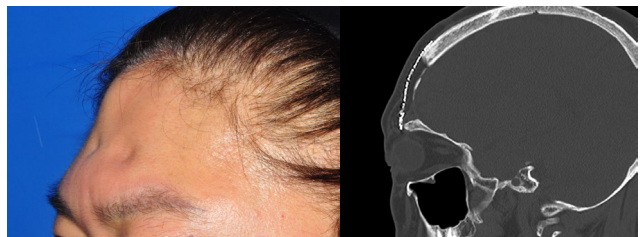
a 58-year-old woman who developed forehead depression and pain after aneurysmal neck clipping via bifrontal approach. Left: preclinical photograph. Right : postoperative 1 year CT, showing well stable titanium mesh and dermofat graft
